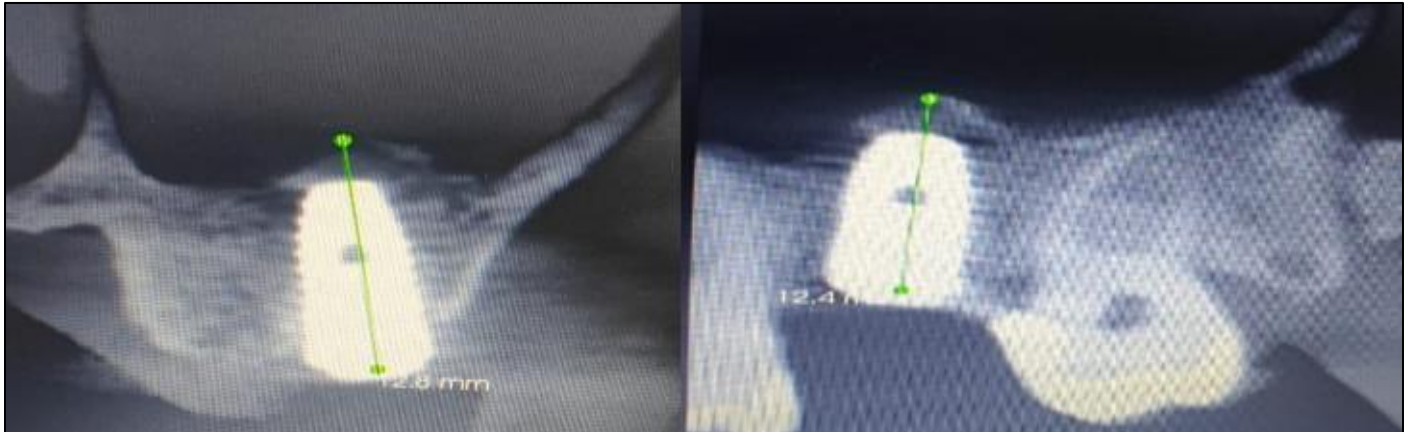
Post-Operative Radiograph(Cbct) After 5 Months
